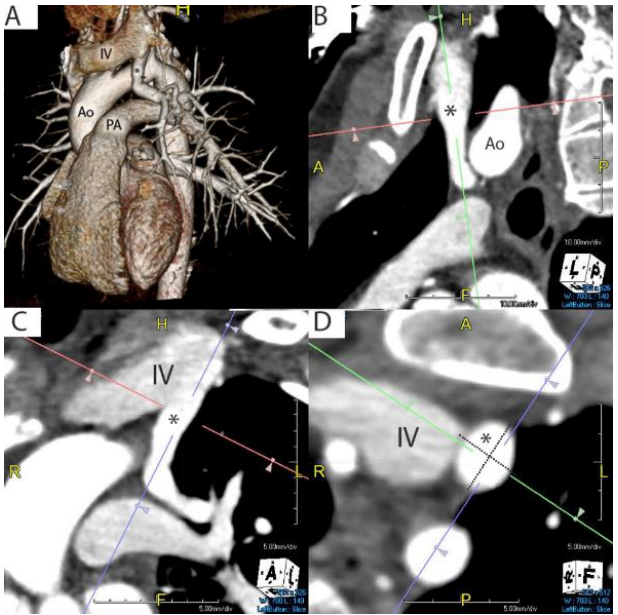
PAPVR as seen on CT. Panel A) Right upper pulmonary vein connecting to superior vena cava (*); Panel B,D,F) corresponding volume rendered image of the same patient. C) Coronal oblique view of the left upper pulmonary vein connecting to the innominate vein (*); E,F) Sagittal oblique image showing the right upper pulmonary vein connecting to the superior vena cava (*)
